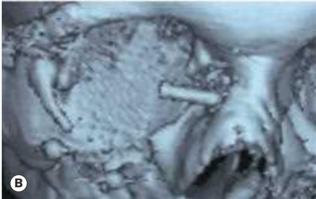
(A) Lester Jones tube; (B) CT scan 3D reconstruction of tube in situ
